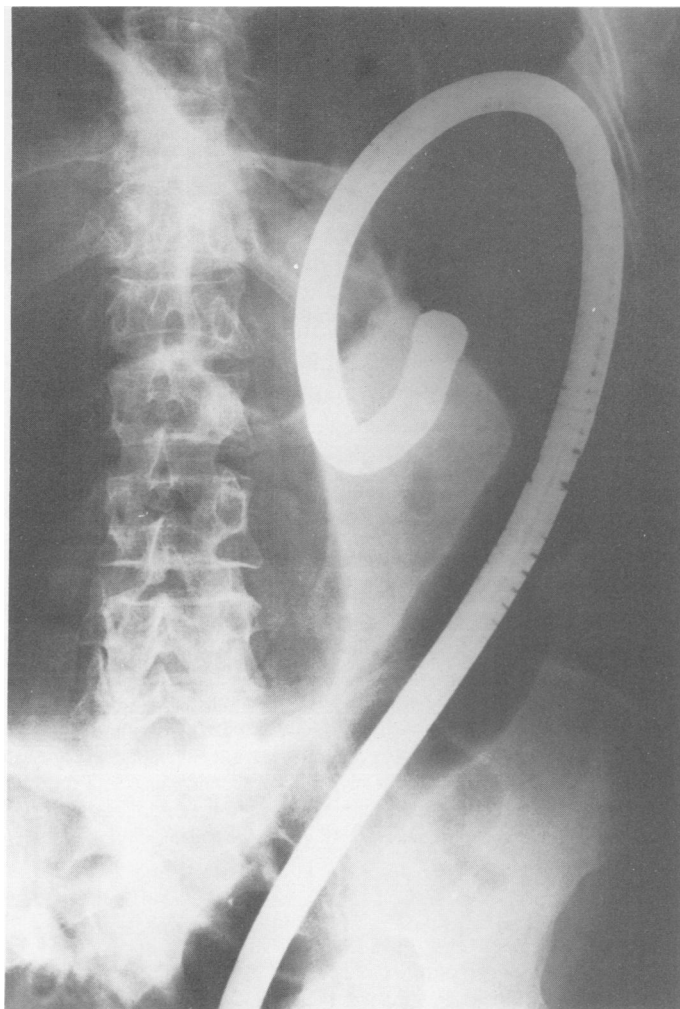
Abdominal radiograph with colonoscope inserted. The tip of the instrument is seen entering the twisted segment of sigmoid colon.
